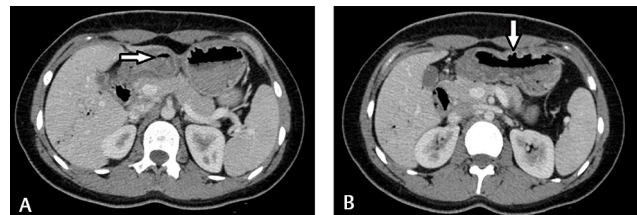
(A) Axial section of contrast-enhanced computed tomography (CECT) of the abdomen showing pneumatosis within the wall of duodenum (arrow). (B) Axial section of CECT of the abdomen showing pneumatosis within the stomach wall with antropyloric wall thickening (arrow).
